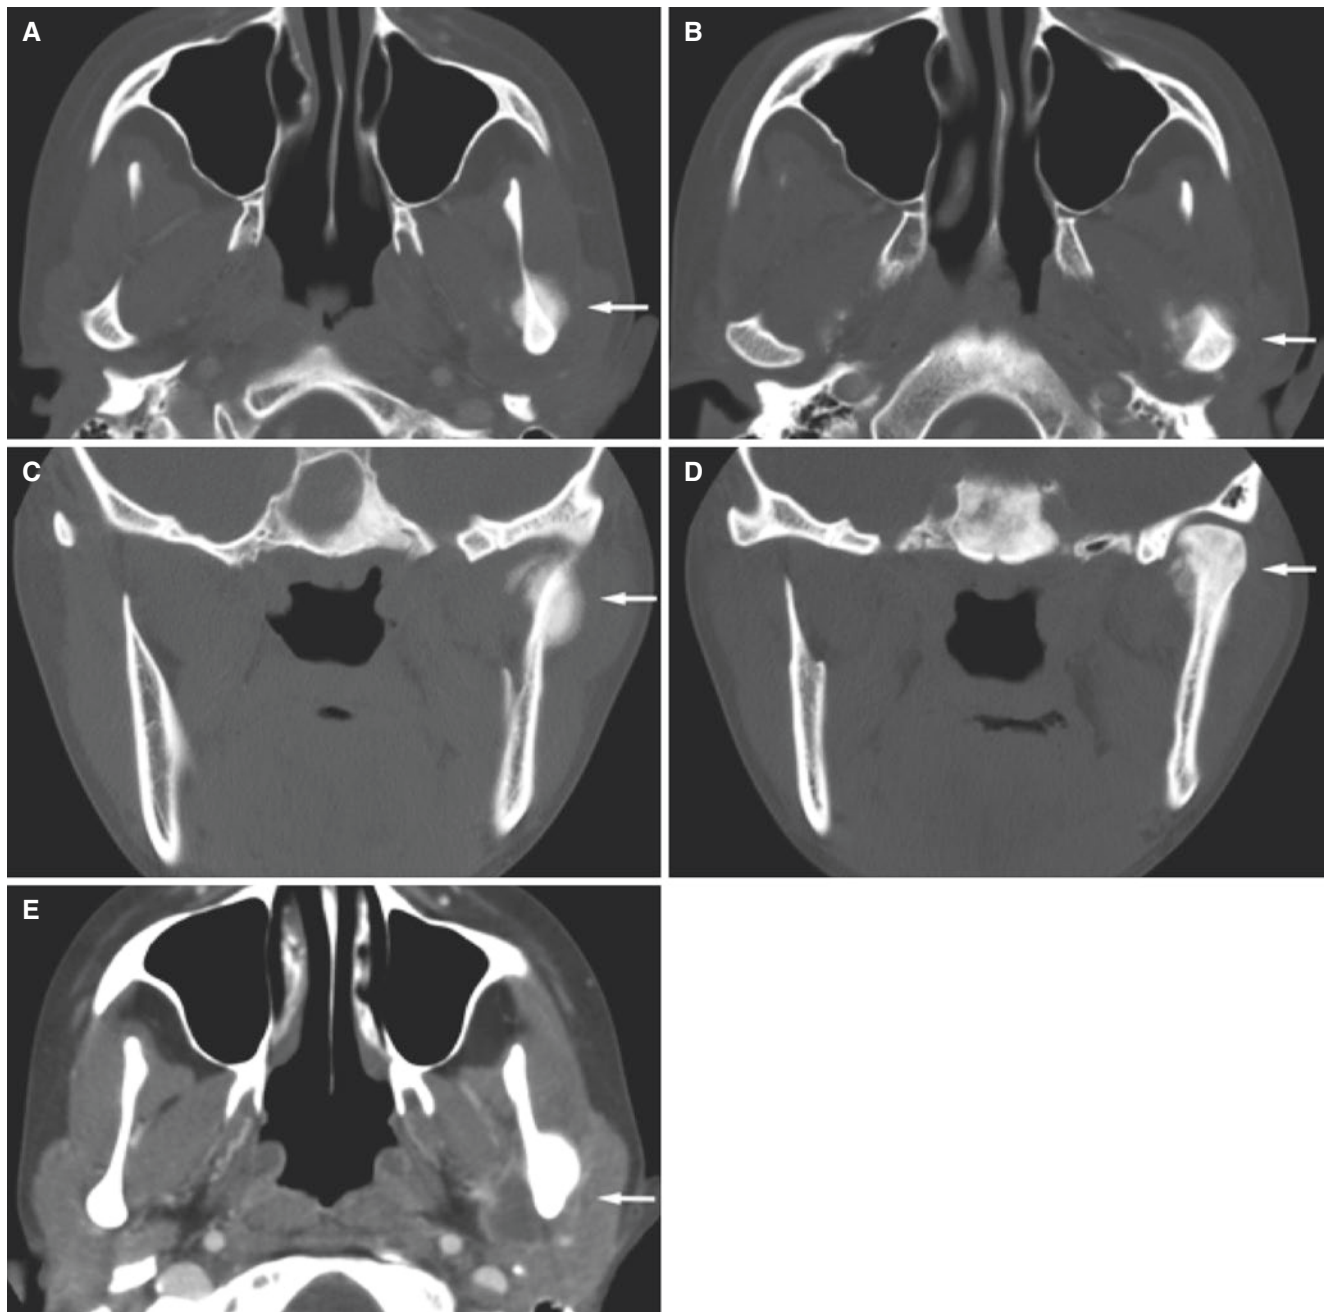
Metastatic osteosarcoma, mandible; 18-year-old female with terminal widespread osteosarcoma (2.5-year history). (A, B) Axial CT images show intense periosteal bone production in the ramus (*arrow*) and in the condyle (*arrow*). (C, D) Coronal CT images show
